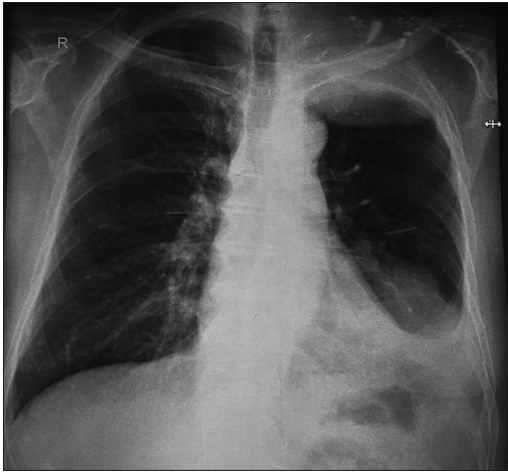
Chest X-ray revealing an opacity located at the apical-subclavicular level and left pulmonary base, along with the lysis of the postero-lateral costal arches of the first three ribs
